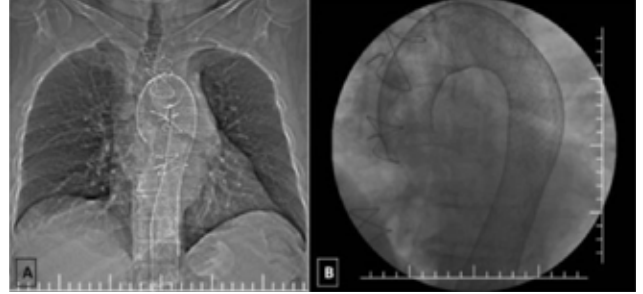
Postoperative computed tomography scan image (A) and angiography viewing (B).
